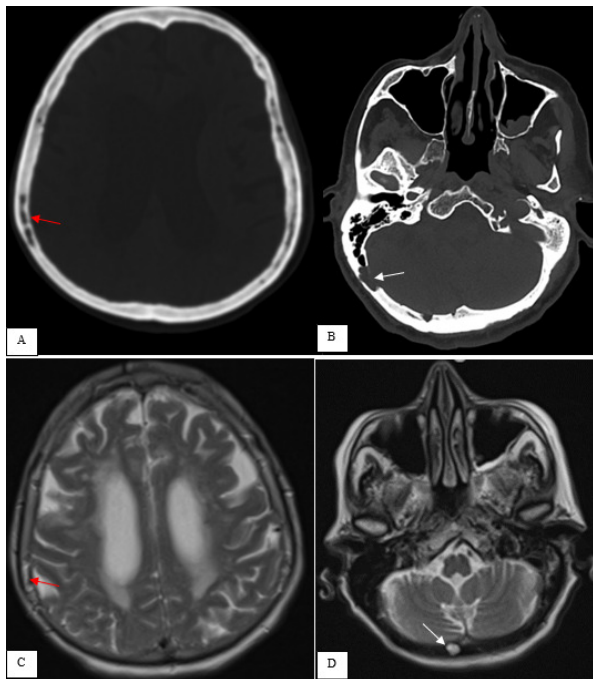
Head CT scan axial images Show the right sided atretic sigmoid sinüs (A, red arrow) and judular bulb (B, white arrow). Compare these with the normal sized left sigmoid sinüs (C, red arrow) and jugular bulb (C, white arrow)
